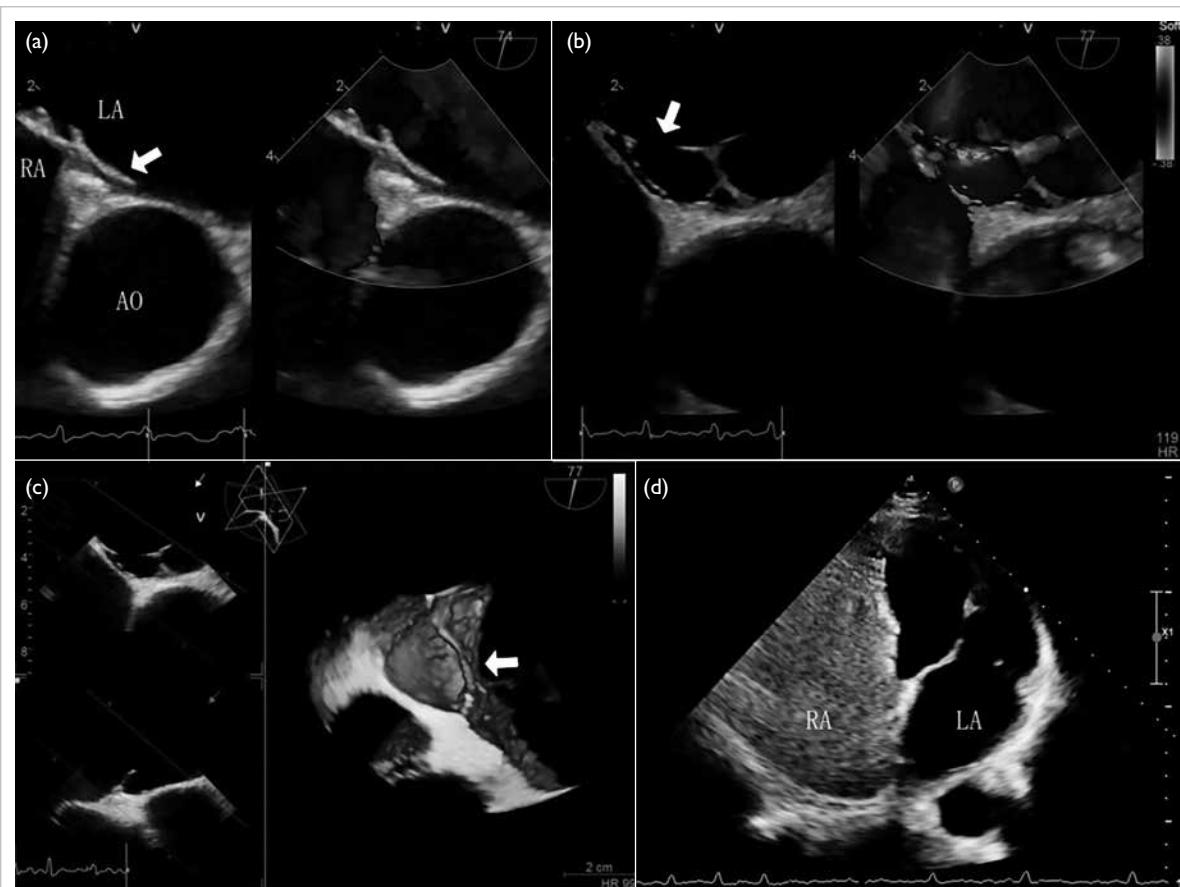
(a) The transoesophageal echocardiography showing a sandwich-like appearance of the foramen ovale during calm breathing (arrow). (b) An irregularly shaped webbed structure with compartmented echoes was identified in the middle of the primary septum (arrow). (c) Three-dimensional transoesophageal echocardiography delineated the webbed structure as sac-like, attached to the primary septum, with a cobweb appearance towards the mitral ring (arrow). (d) Right echocardiography confirmed the absence of contrast in the left atrium
